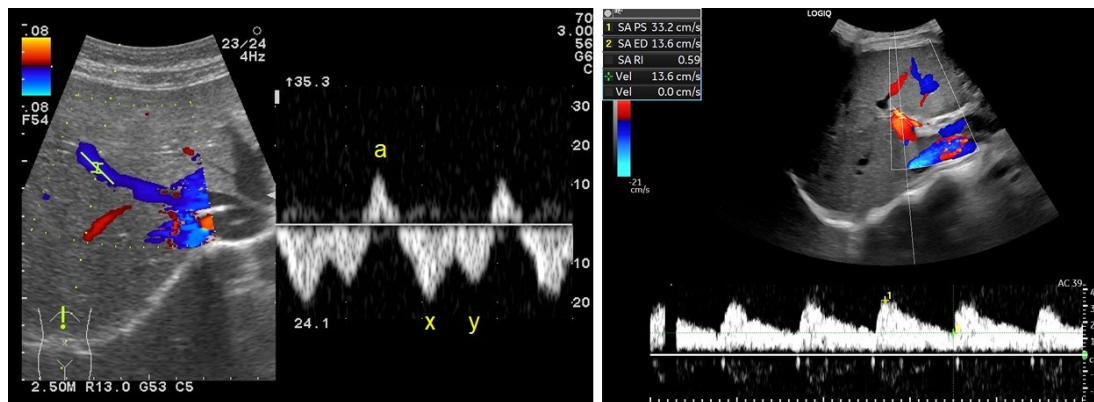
a.3. Spectral Doppler imaging of the hepatic vein (left panel) and hepatic artery (right panel) in a healthy person. Note triphasic waveform from the hepatic vein, and low resistance arterial waveform from the hepatic artery (normal peak systolic, end diastolic velocities and resistive index).
